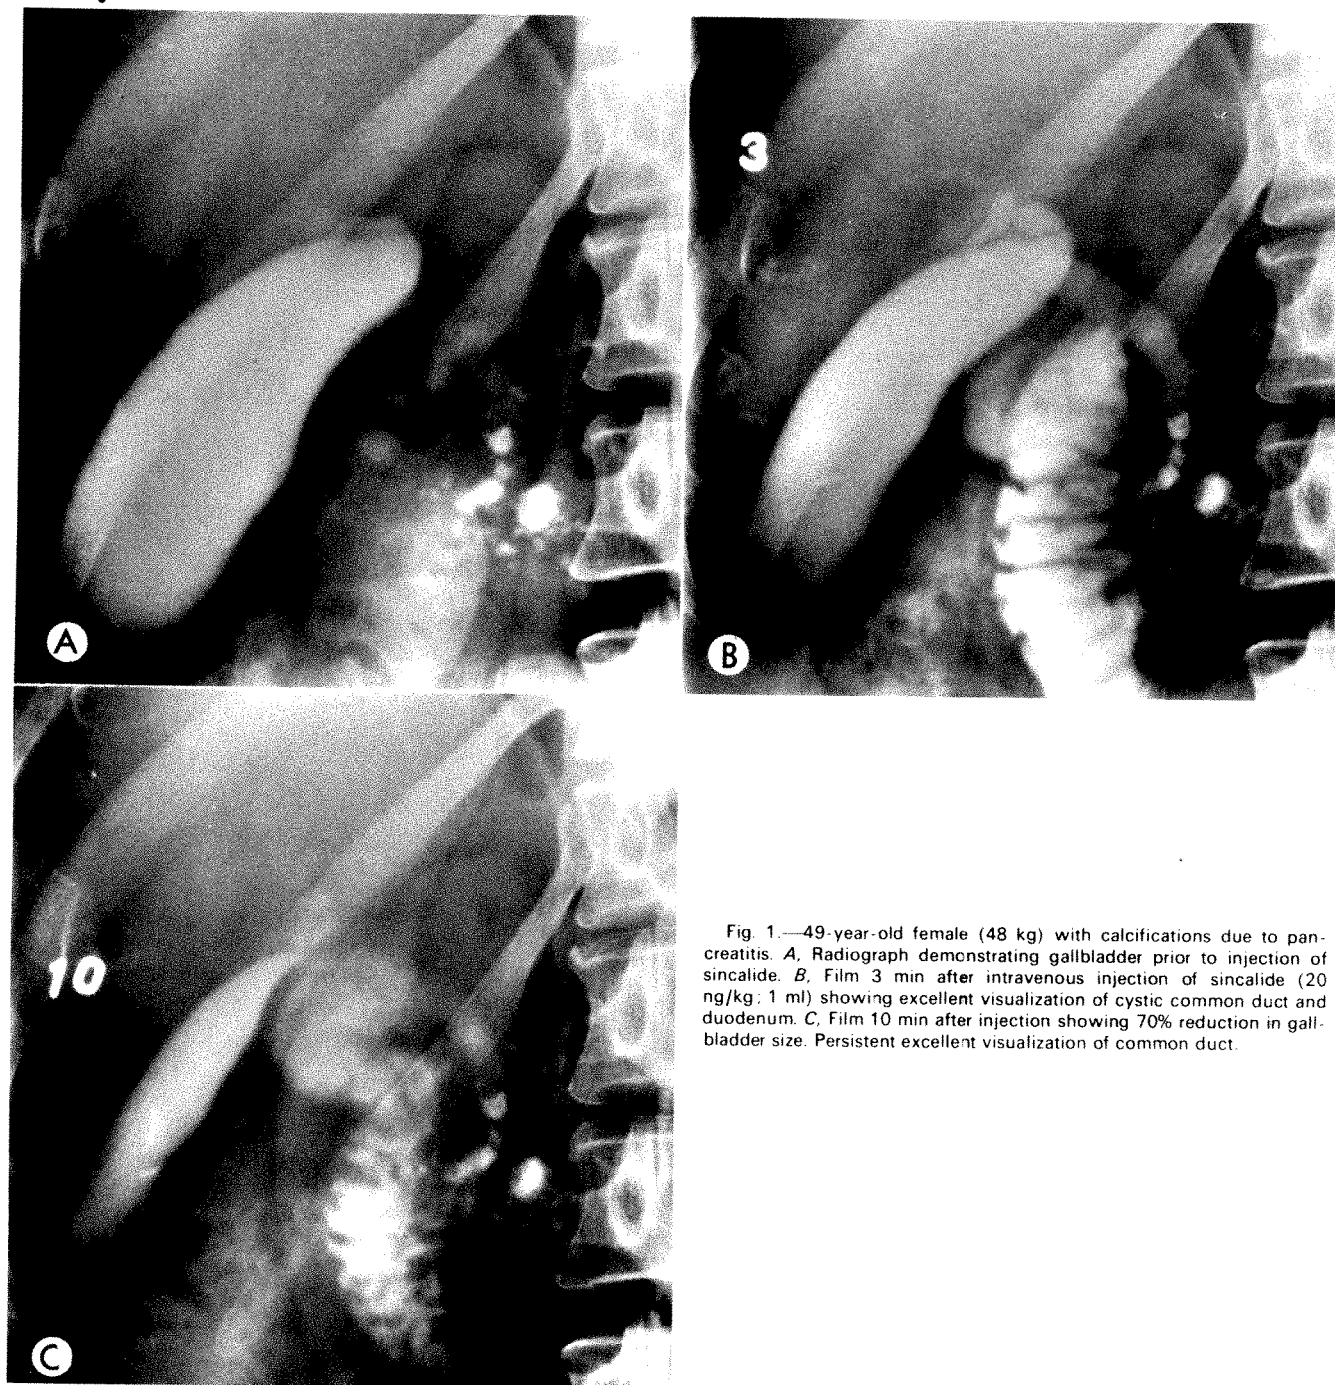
49-year-old female (48 kg) with calcifications due to pancreatitis. A, Radiograph demonstrating gallbladder prior to injection of sincalide. B, Film 3 min after intravenous injection of sincalide (20 ng/kg; 1 ml) showing excellent visualization of cystic common duct and duodenum. C, Film 10 min after injection showing 70% reduction in gallbladder size. Persistent excellent visualization of common duct.
